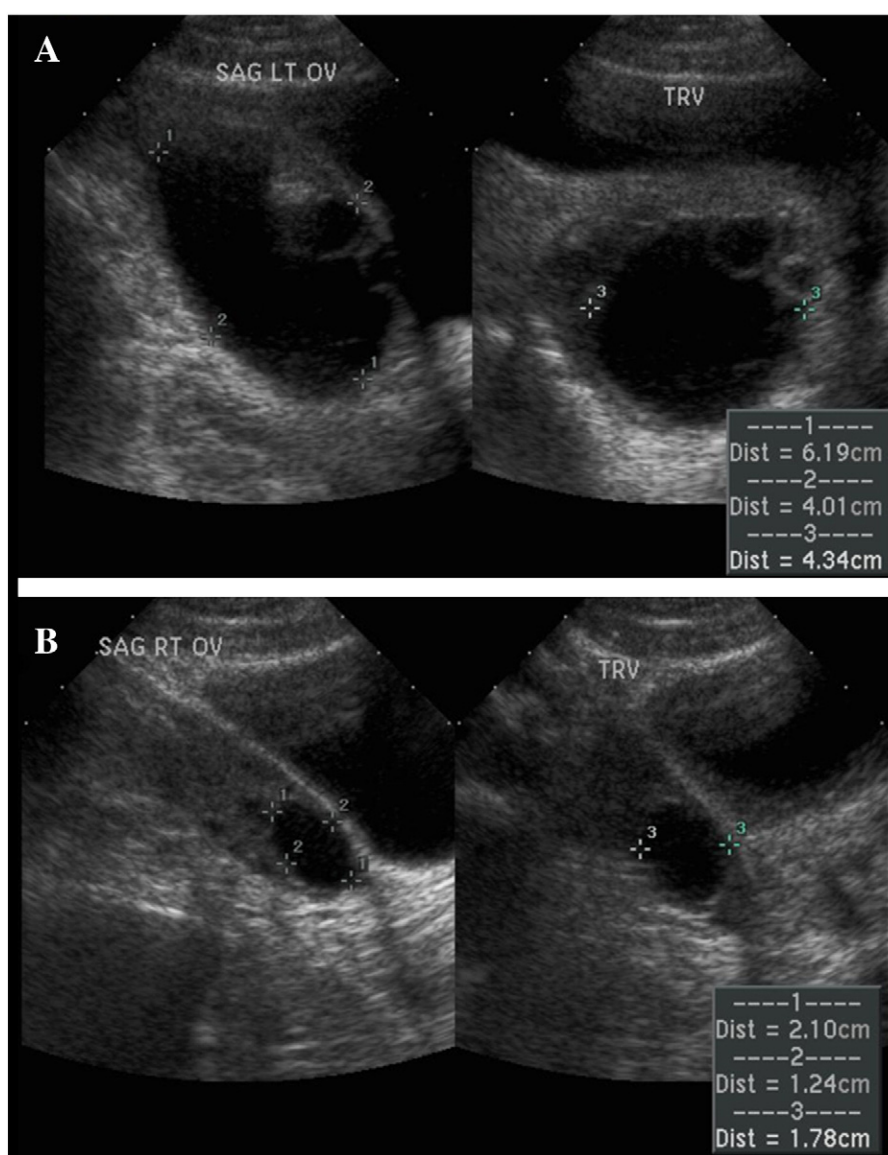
Transabdominal ultrasonography demonstrates a $6.2 \times 4.0 \times 4.3$ -cm cystic mass in the left ovary (panel A) compared to a normal-appearing right ovary (panel B).
